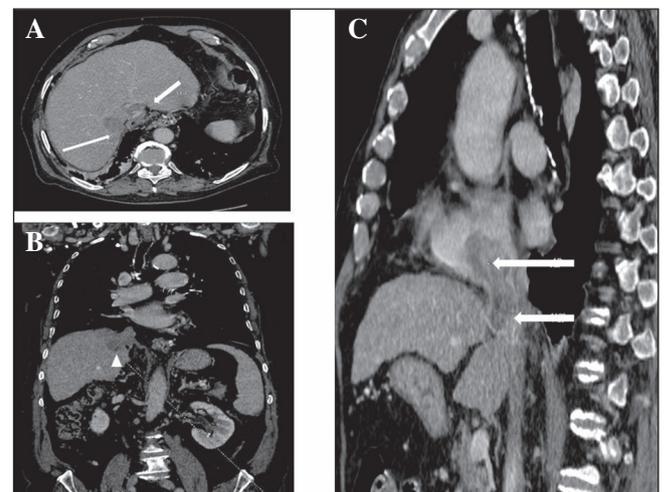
CT. A. Axial section at abdominal level with a focal liver lesion (lower arrow) and IVC (upper arrow). B. Coronal section showing that the mass extends to the right cardiophrenic space (arrowhead). C. Heterogeneous and multi-lobulated mass inside the RA (upper arrow) extending to the IVC in its intrahepatic path (lower arrow).
